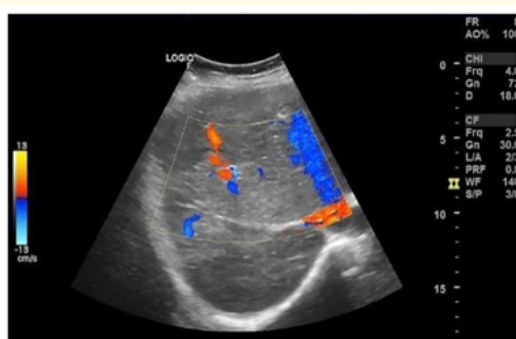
Ultrasound view, to be noted thrombosis of right prehepatic vein, hyperechoic without doppler signal.
